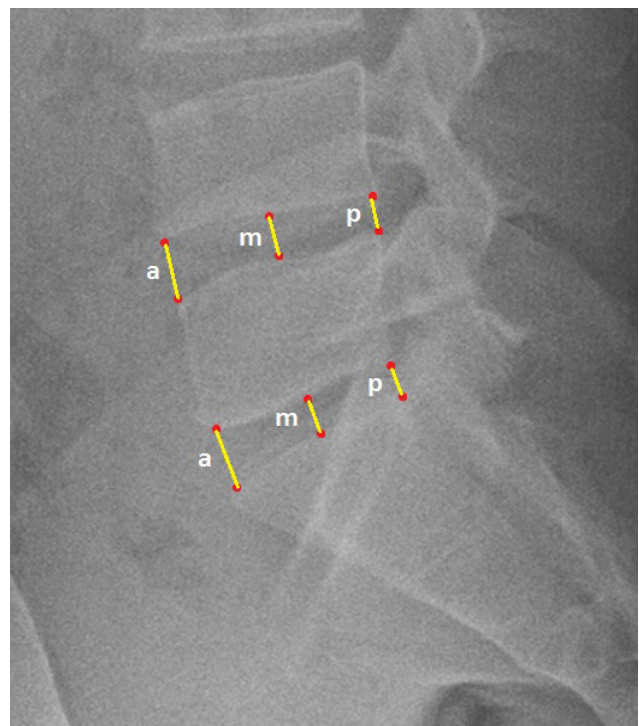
The anterior (a), middle (m), and posterior (p) measurements of intervertebral disc space heights on lateral lumbar spine radiographies
